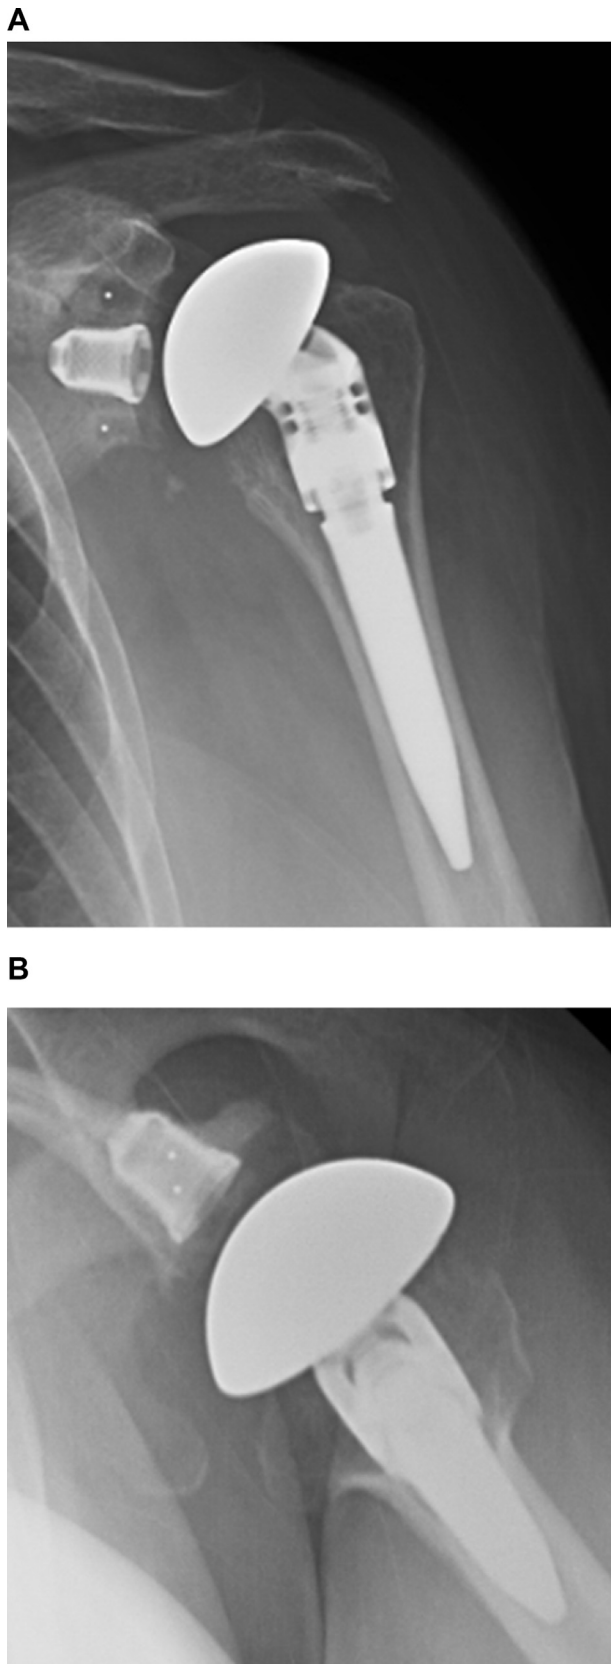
(A) Anteroposterior and (B) axillary postoperative radiographs of the left shoulder after anatomic total shoulder arthroplasty showing stable implants in anatomic position.
